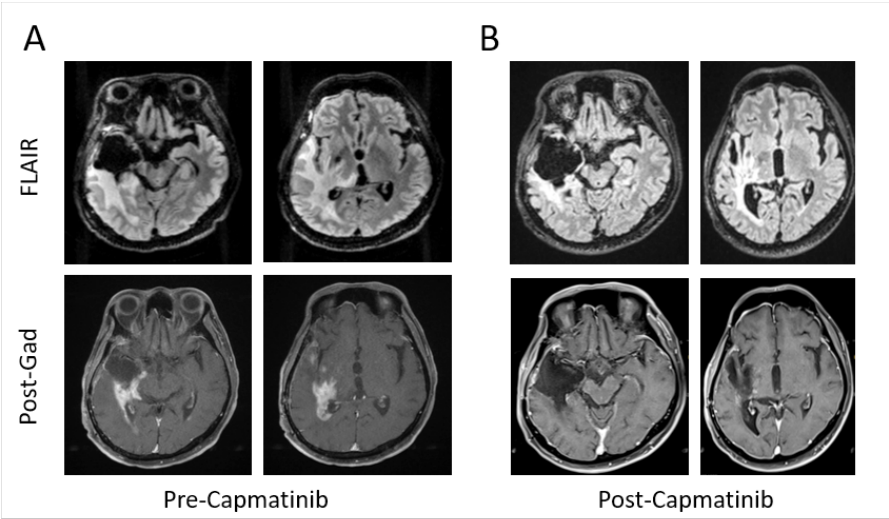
Therapeutic Response to Capmatinib Therapy. A: Brain MRI from February of 2021. B: Brain MRI from December of 2021. Abbreviations: FLAIR, fluid-attenuated inversion recovery; Gad, gadolinium.
